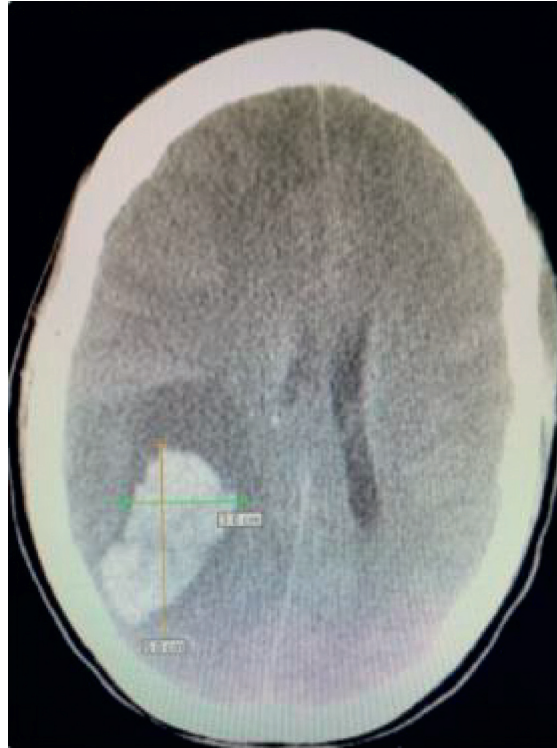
Computerized tomography (CT) axial head without contrast showing intraparenchymal hemorrhage and secondary mass effect.
